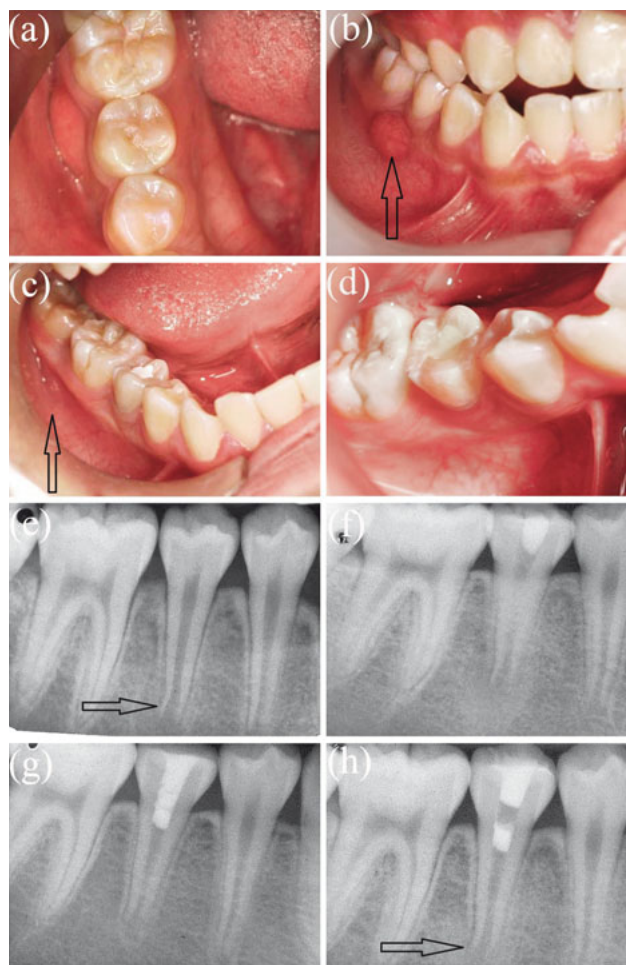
Case 3 intraoral photographs and periapical radiographs. a) Pre-treatment occlusal photograph of the mandibular right second premolar (tooth 45); b) pre-treatment intraoral photograph showing the draining sinus tract on the buccal side (arrow); c) intraoral photograph 2 weeks later; the draining sinus tract had disappeared (arrow); d) intraoral photograph at the 8-month follow-up; e) pre-treatment periapical radiograph of tooth 45 showing the periapical radiolucency and immature root (arrow); f) periapical radiograph taken after filling with calcium hydroxide paste; g) periapical radiograph taken 2 weeks later after filling with mineral trioxide aggregate (MTA); h) periapical radiograph taken at the 8-month follow-up; the root canal had lengthened and the root wall had thickened (arrow).
